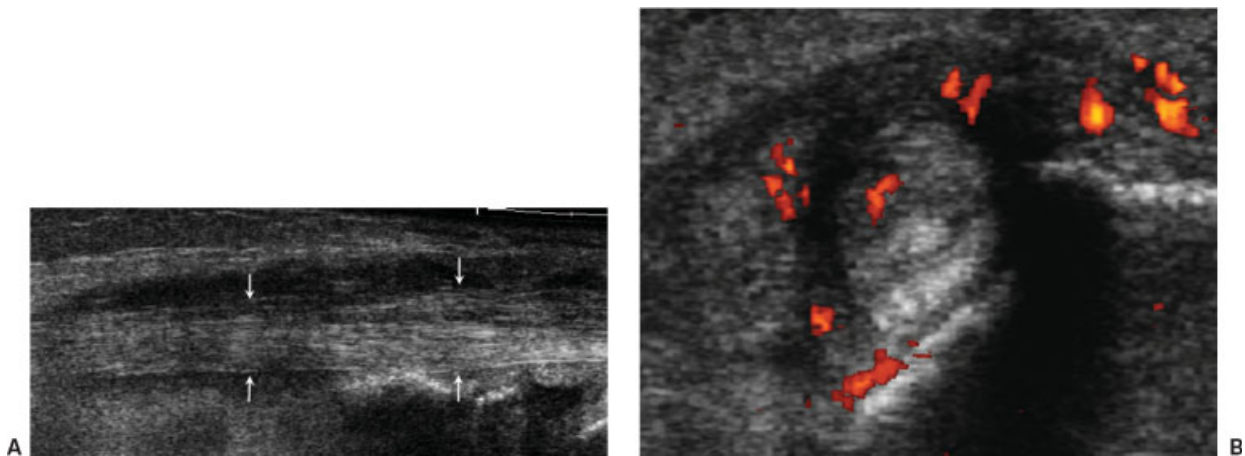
Posterior tibial tenosynovitis and tendinosis. (A) Panoramic longitudinal and (B) transverse scans of posterior tibial tendon show fluid distending the tendon sheath and associated tendinosis, with tendon thickening (arrows) and heterogeneous echotexture and probable intrasubstance longitudinal partial tears. Color Doppler in (B) shows increased blood flow to the region.
